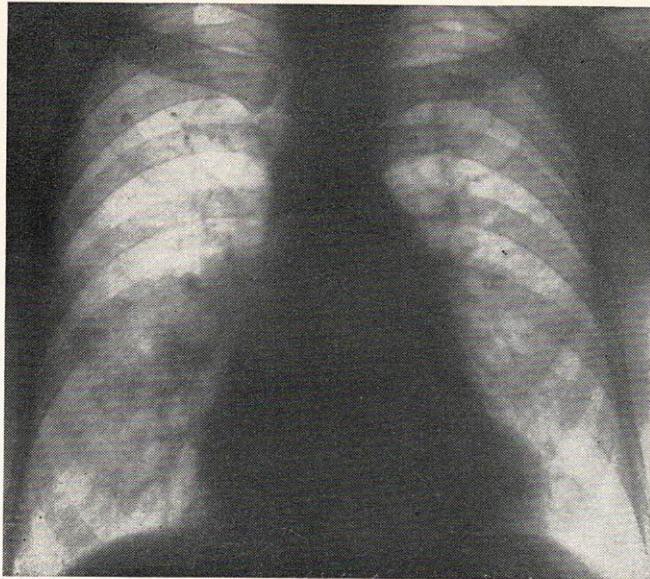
Posteroanterior X-ray. Increased transradiancy and lack of vascular markings in the right upper field.
